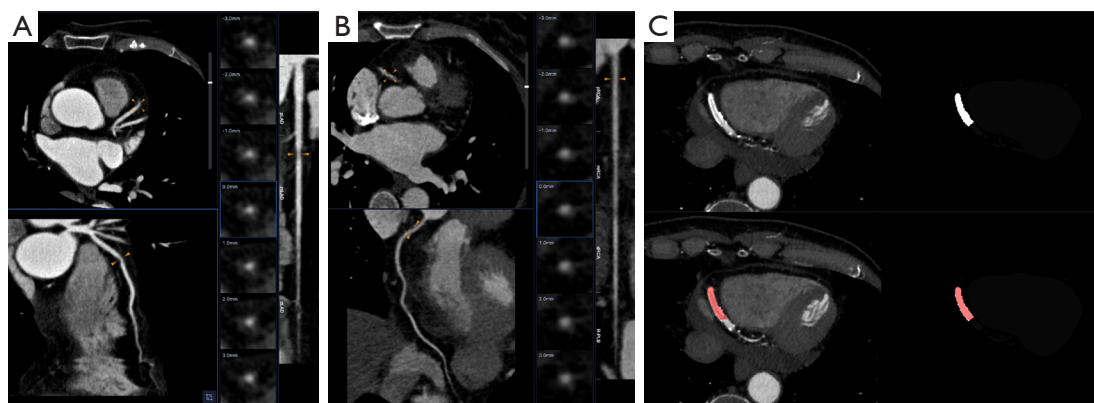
Example cases of the AI-based CAD-RADS categorization and stent segmentation. (A) A 69-year-old female with an LAD stenosis severity of CAD-RADS 3: axial view (top left), curved multiplanar reformatted image (bottom left), multiplanar along the centerline (second from right), and straightened MPR (right). AI identified a 54% stenosis (orange arrowheads) in the middle vessel segment. (B) A 57-year-old female with an RCA stenosis severity of CAD-RADS 1: axial view (top left), curved multiplanar reformatted image (bottom left), multiplanar along the centerline (second from right), and straightened MPR (right). AI identified a 19% stenosis (orange arrowheads) in the proximal vessel segment. (C) A 79-year-old male with a stent in the distal RCA: axial view of CCTA (top left), reference standard for stent volume (top right), AI-based stent segmentation prediction on CCTA (bottom left), and AI-based prediction compared to the reference standard (bottom right). AI, artificial intelligence; CAD-RADS, Coronary Artery Disease Reporting and Data System; LAD, left anterior descending artery; RCA, right coronary artery; MPR, multiplanar reformatted; CCTA, coronary computed tomography angiography.
